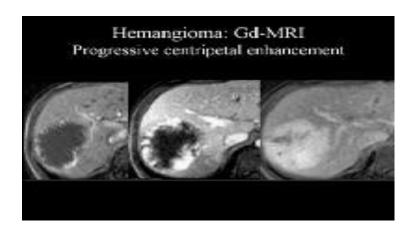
Dynamic gadolinium (Gd)-enhanced magnetic resonance images (MRIs). These images demonstrate the progressive, centripetal contrast enhancement in a hemangioma.
